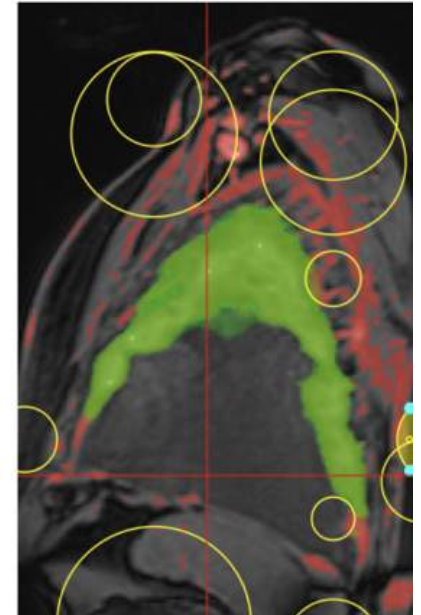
Semi-automated volume segmentation in a patient with MPM at contrast-enhanced MRI, in coronal (Panel A), axial (Panel B) and sagittal (Panel C) planes, using the MIAlite plugin for OsiriX. Areas of similar signal intensity to the 'seeding circles' (not shown) are highlighted in red. The yellow 'blocking circles' are placed to prevent seeding in to adjacent structures. The final segmented volume is highlighted in green.
